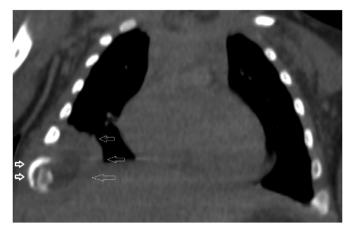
Coronal CT image demonstrates cortical expansion and interruption of rib (thick arrows). Adjacent inhomogeneous mass with more central hypoattenuating component (thin arrows).
